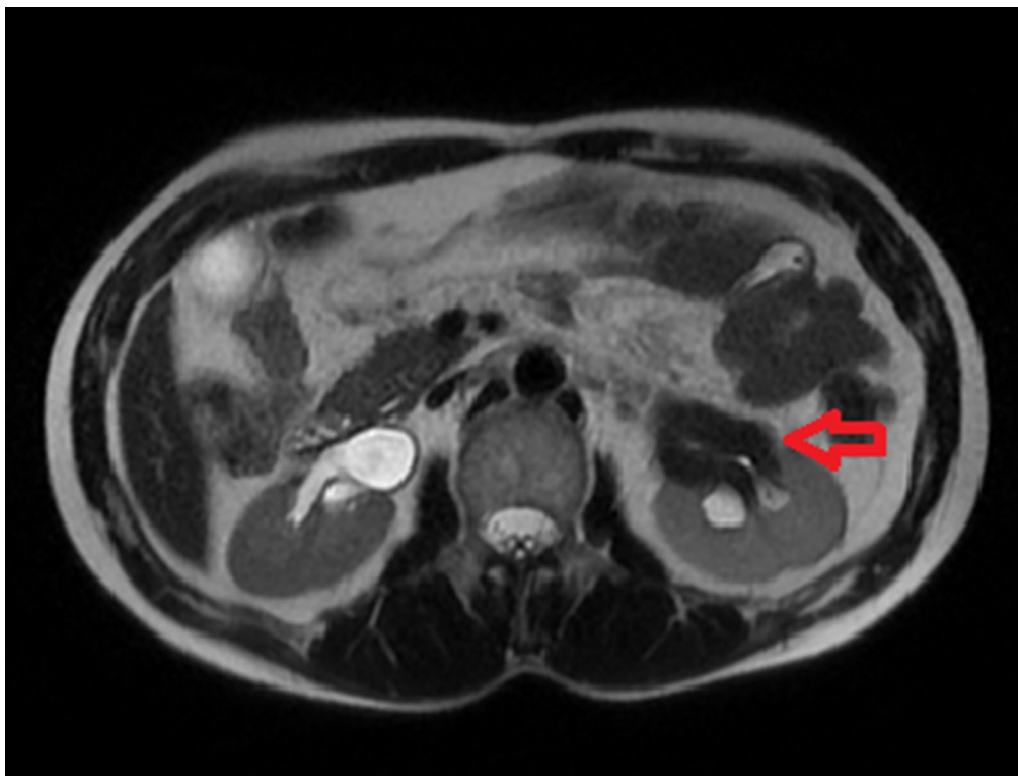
Abdominal MR image of our patient during the initial diagnosis
